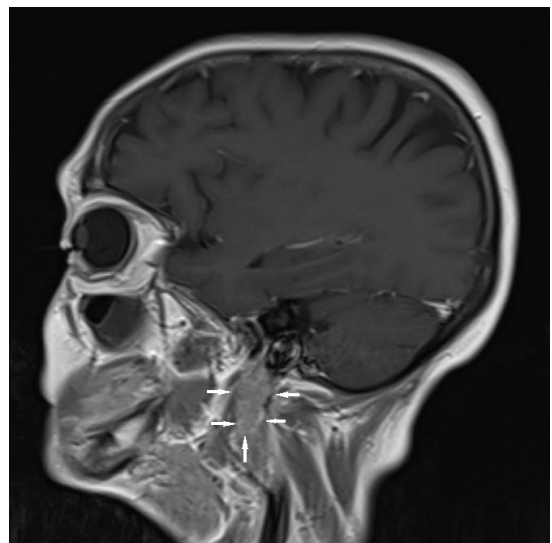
Sagittal contrast-enhanced T1 weighted magnetic resonance image shows a well defined, lobulated, diffusely enhancing mass of the right jugular foramen with an extracranial extension (white arrows)
